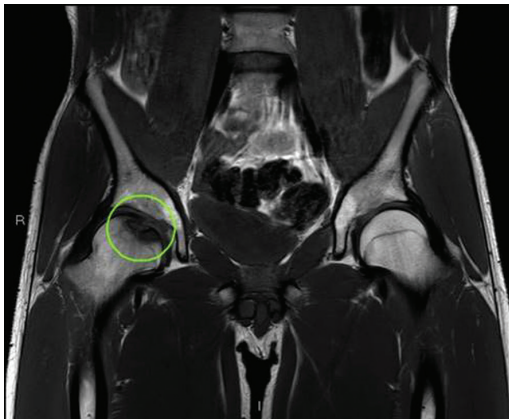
Hypointense T1 signal sclerosis and collapse of the bone fragment with a peripheral rim of hypointense signal on MRI.
